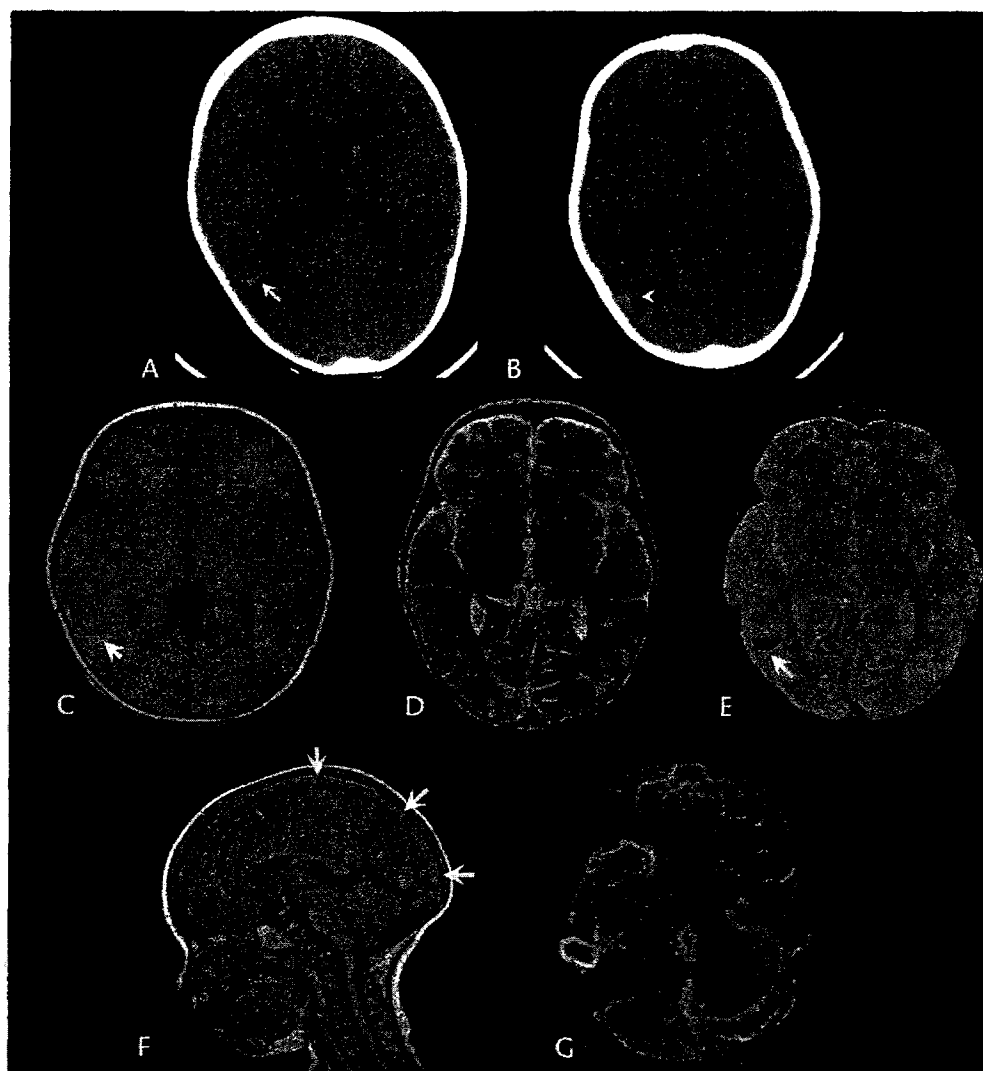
Images obtained from a 22-month-old boy who experienced lethargy, vomiting, and seizures after a viral illness, plus thrombocytopenia and iron deficiency anemia. A–B, Computed tomographic images show right-side posterior temporal and peritentorial high-density foci of hemorrhage or thrombosis (arrows). Axial T1 (C), T2 (D), and GRE (E) images show corresponding T1-hyperintense and GRE-hypointense foci with associated T2 hyperintensity (arrows). F, Sagittal T1 MRI scan shows hyperintensity along the superior sagittal sinus (arrows [thrombosis vs slow flow]). G, Axial MRV projection image shows nonvisualization of the superior sagittal, right-side transverse, and right-side sigmoid sinuses (diagnosis, postviral dural and cerebral venous thrombosis [extensive coagulopathy workup continues]).
